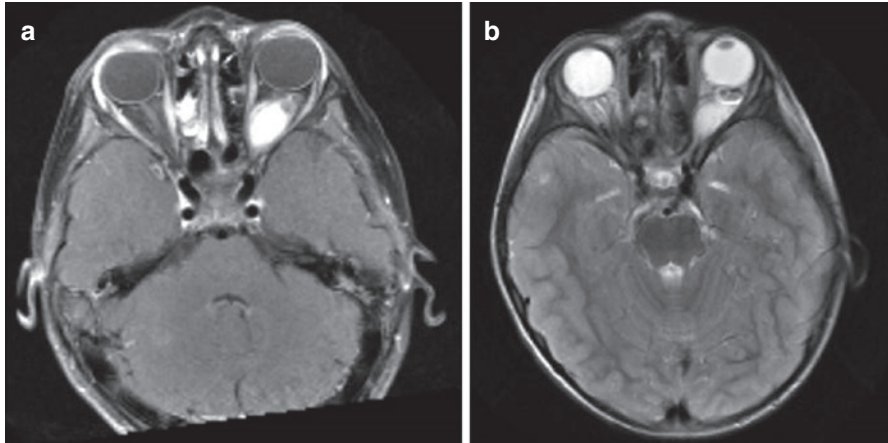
Left optic nerve glioma (a) enhancing on contrast-enhanced T1-weighted magnetic resonance sequence and (b) hyperintense on a contrast-enhanced T2-weighted magnetic resonance sequence
